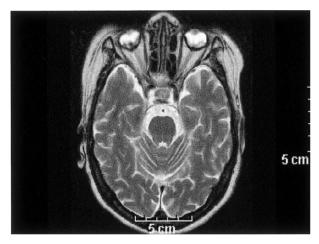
Brain MRI, showing no abnormal signal intensity or abnormal mass lesion in T2WI. The ventricular system was within normal limits
